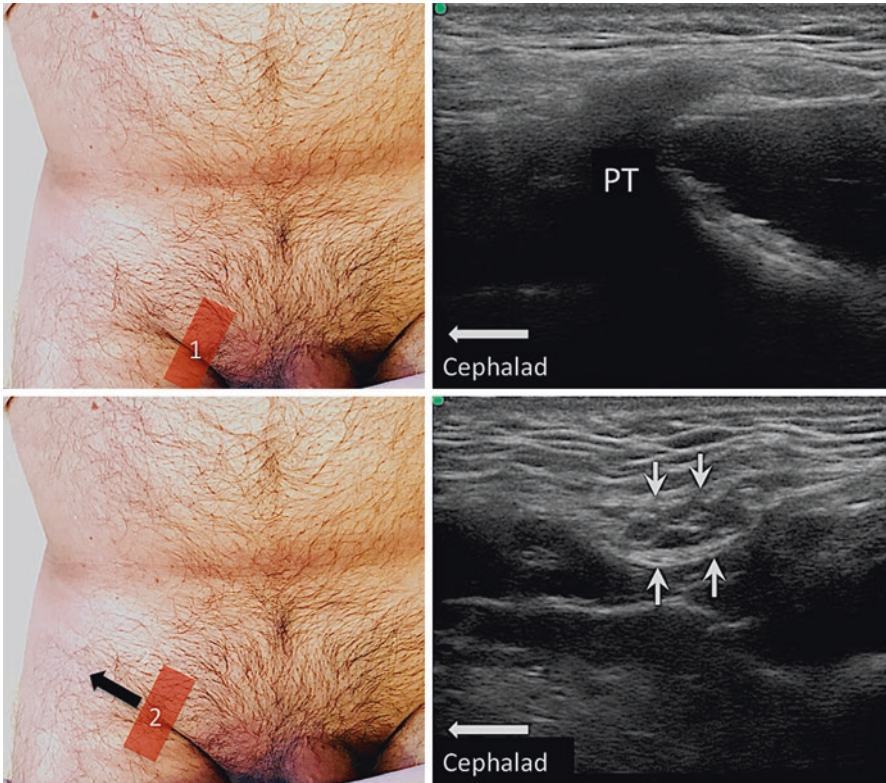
Position of ultrasound probe at and lateral to the pubic tubercle (PT) and the corresponding sonography. The spermatic cord was outlined with arrows. (Reprinted with permission from Philip Peng Educational Series)
